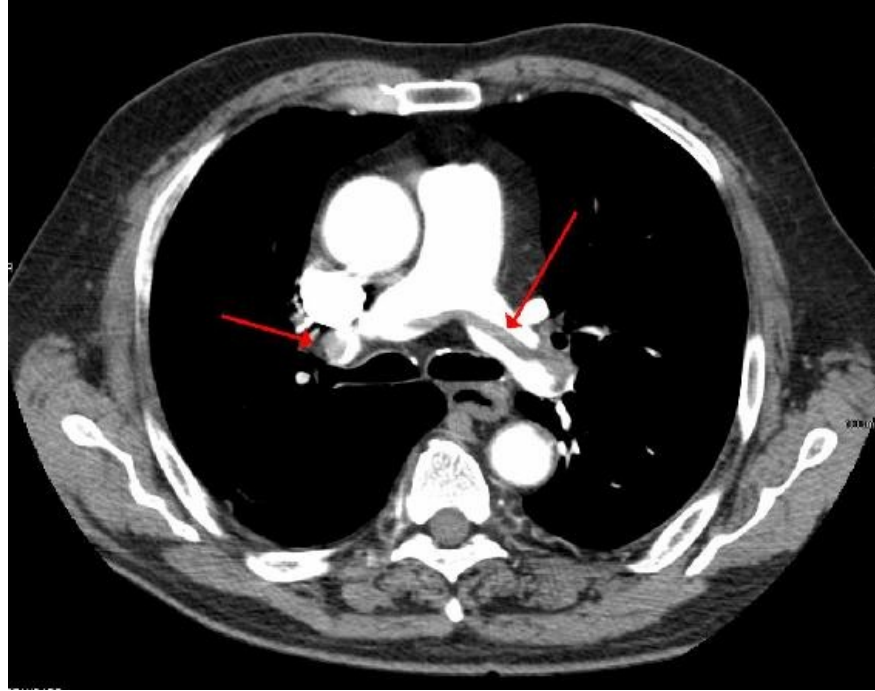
Pulmonary Embolism CT
